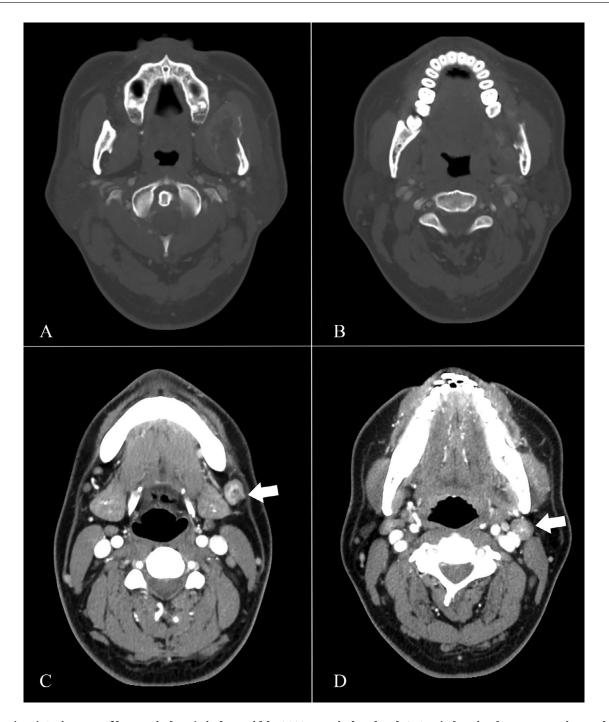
(A, B) CT images of bone window (window width: 2000HU, window level: 350HU) showing bone expansion and cortical bone perforation adjacent to the lesion. (C, D) Two enlarged lymph nodes were observed in the left IB and II region (arrows).
